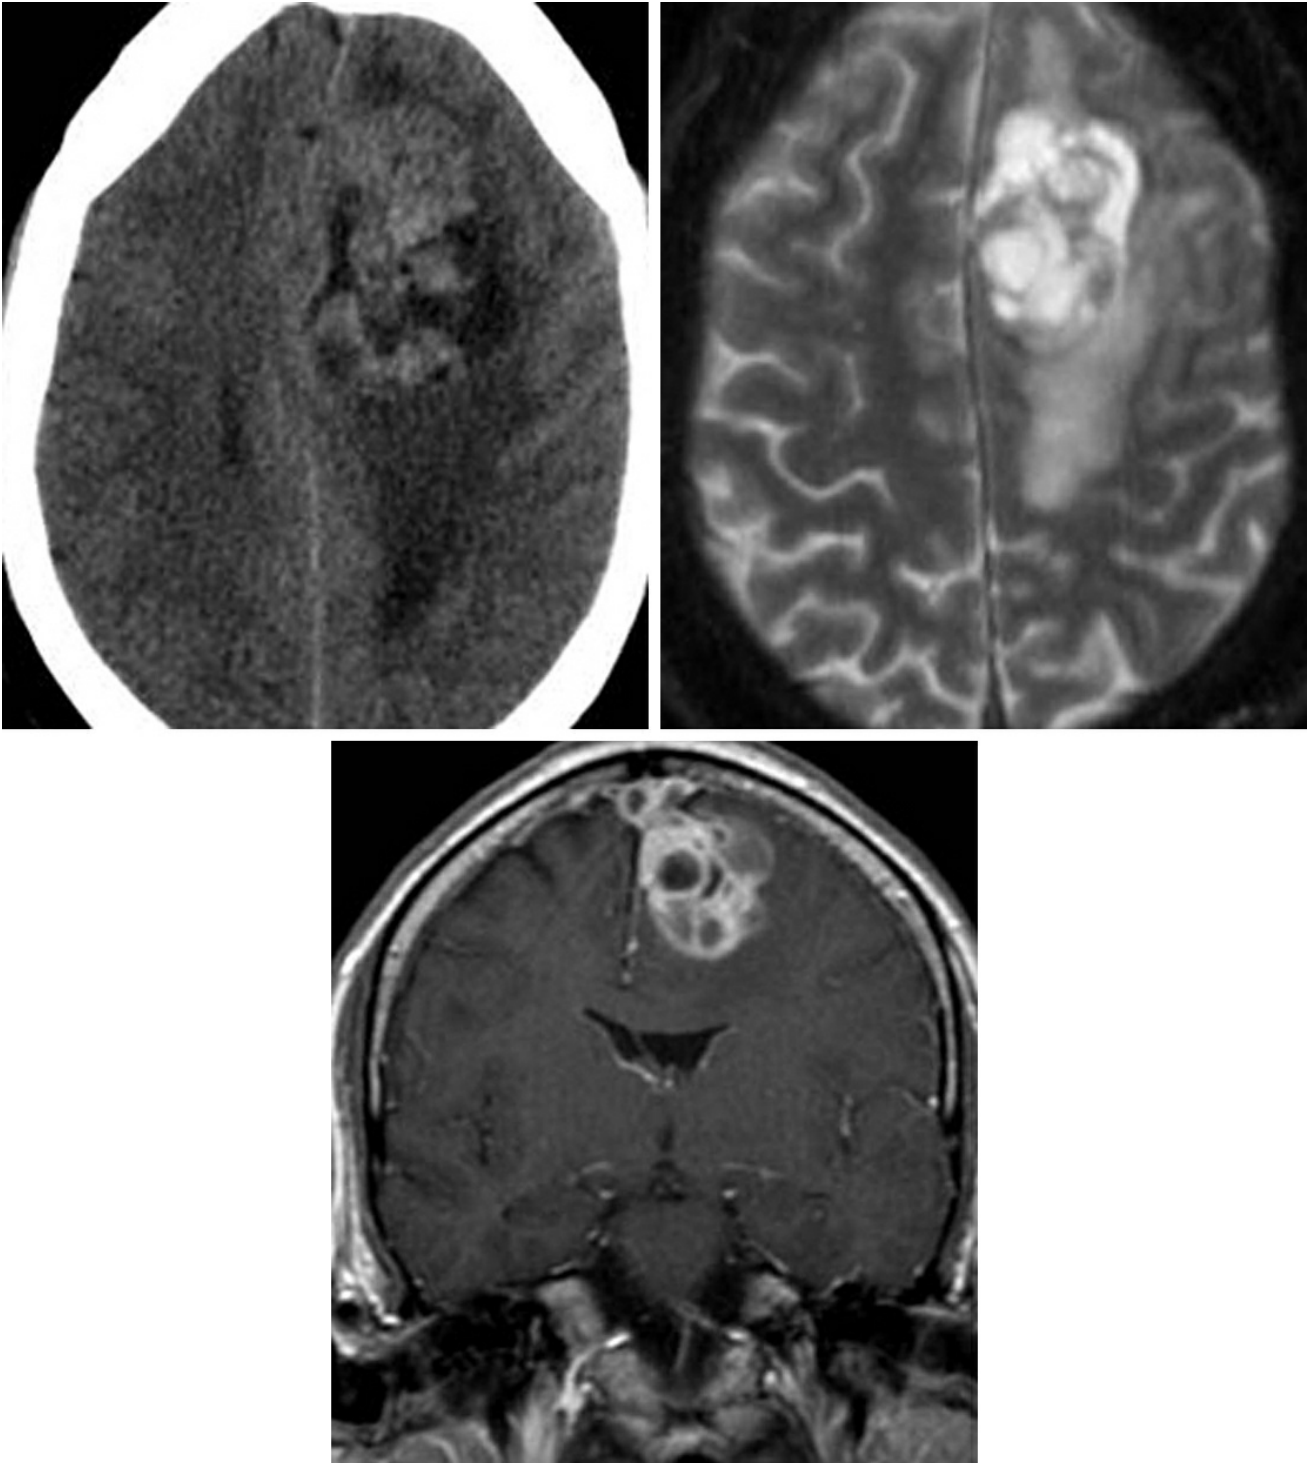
(Top Left) This hemangiopericytoma demonstrates complexity, cystic change, and hyperdensity on CT imaging. (Top Right) The cystic changes and surrounding edema are even more evident on T2WI.
